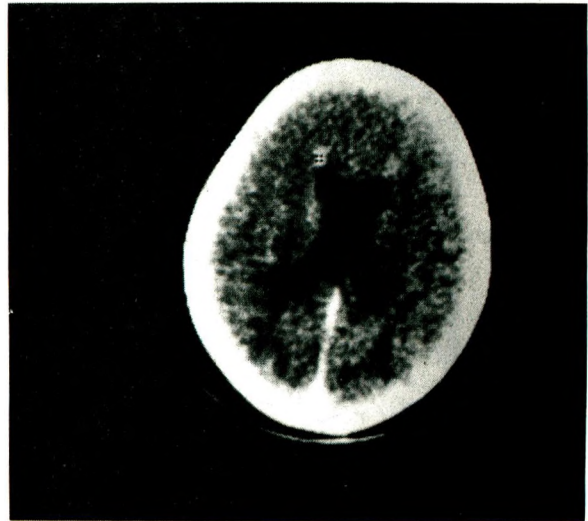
CT scan on the thirteenth day of the illness revealed bilateral contrast enhancement in front of the frontal horn.
